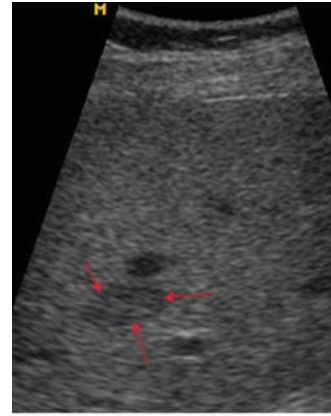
Hepatocellular carcinoma of the right hepatic lobe. A 1.9 cm solid lesion (arrows) located in segment six of the liver was picked up with reasonable ease on ultrasound. This 32-year-old female of Chinese origin was infected with HBV through blood transfusion at an early age. The lesion was proven to be HCC at biopsy. No alpha-fetoprotein testing had been conducted prior to this ultrasound.
